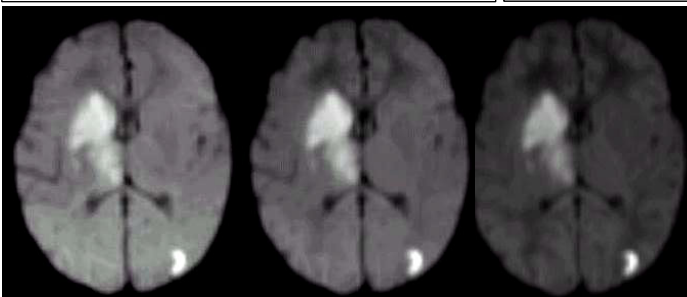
Newborn DWI images at b values of 700 (left), 1000 (middle) and 1500 (right) s/mm².
